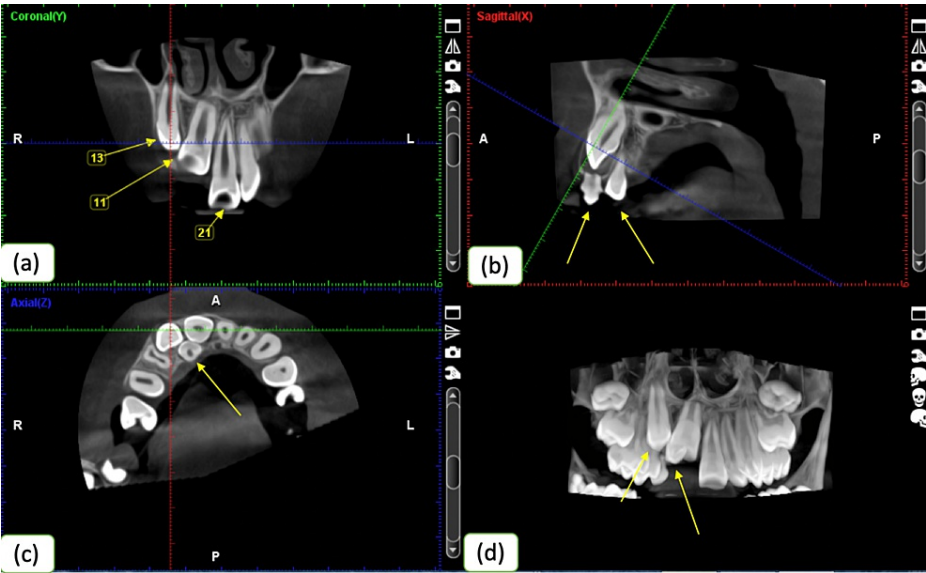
CBCT showing the position of the impacted teeth: (a) coronal section, (b) sagittal section, (c) axial section, and (d) 2D image
